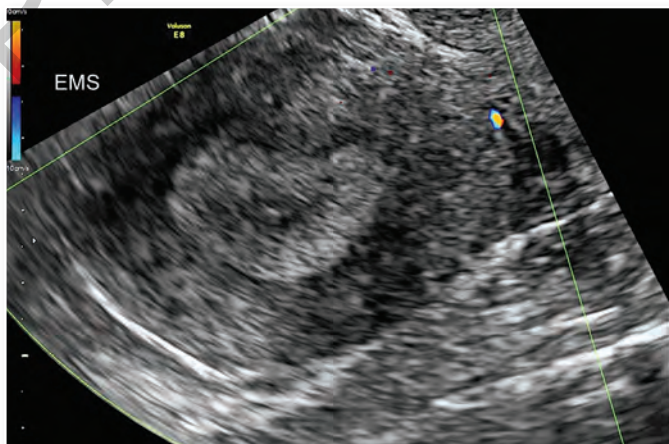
Transvaginal color Doppler image of the uterus demonstrates thick avascular endometrium (maximal thickness of 16 mm)
